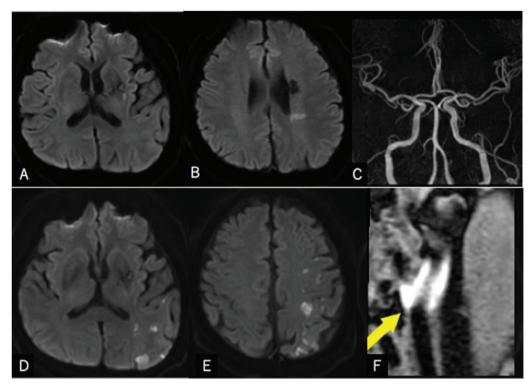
(A and B) Diffusion-weighted head MRI on admission. Acute cerebral infarction was observed from the left putamen to the corona radiata. (C) Head MRA. No occlusion of major arteries was noted. (D and E) Diffusion-weighted head MRI on the 16th hospital day. Multiple cerebral infarctions not observed on admission appeared in the territory of the left meddle cerebral artery. (F) Black-blood MRI on the 17th hospital day. Sagittal T1WI. Hyper-intense vulnerable plaque was noted by T1WI in the left cervical internal carotid artery (arrow).
